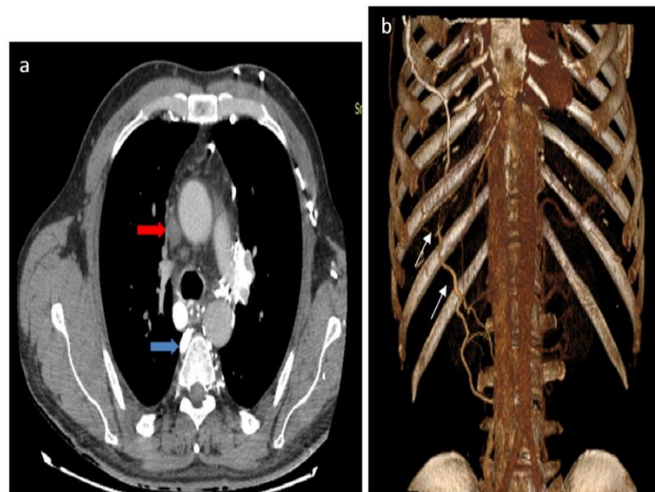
a-Transverse CT scan through the level of upper mediastinum revealing a thrombosed SVC (red arrow) with dilated azygos vein (blue arrow). b- Coronal 3D-VR showing multiple anterior chest wall collaterals (white arrows).
